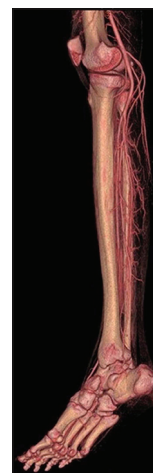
CT angiography showing the perforators of the posterior tibial artery
